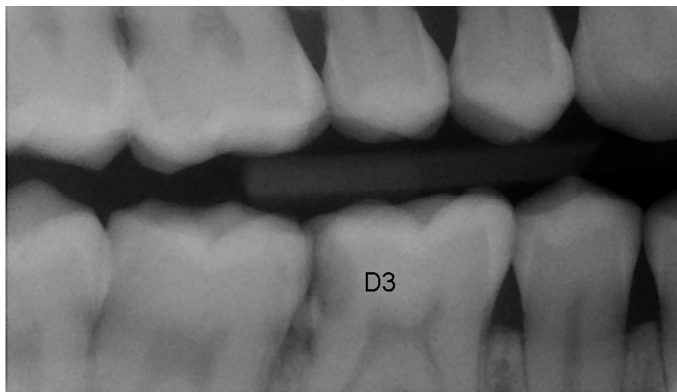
Digital Bitewing Radiograph showing scoring
